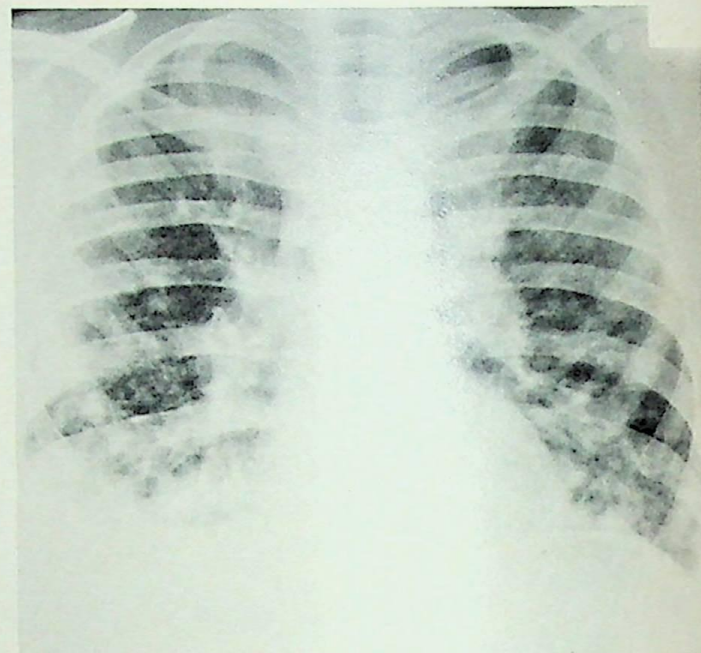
Roentgenographic demonstration of nodular pneumonic infiltrate in patient with Churg-Strauss syndrome.
